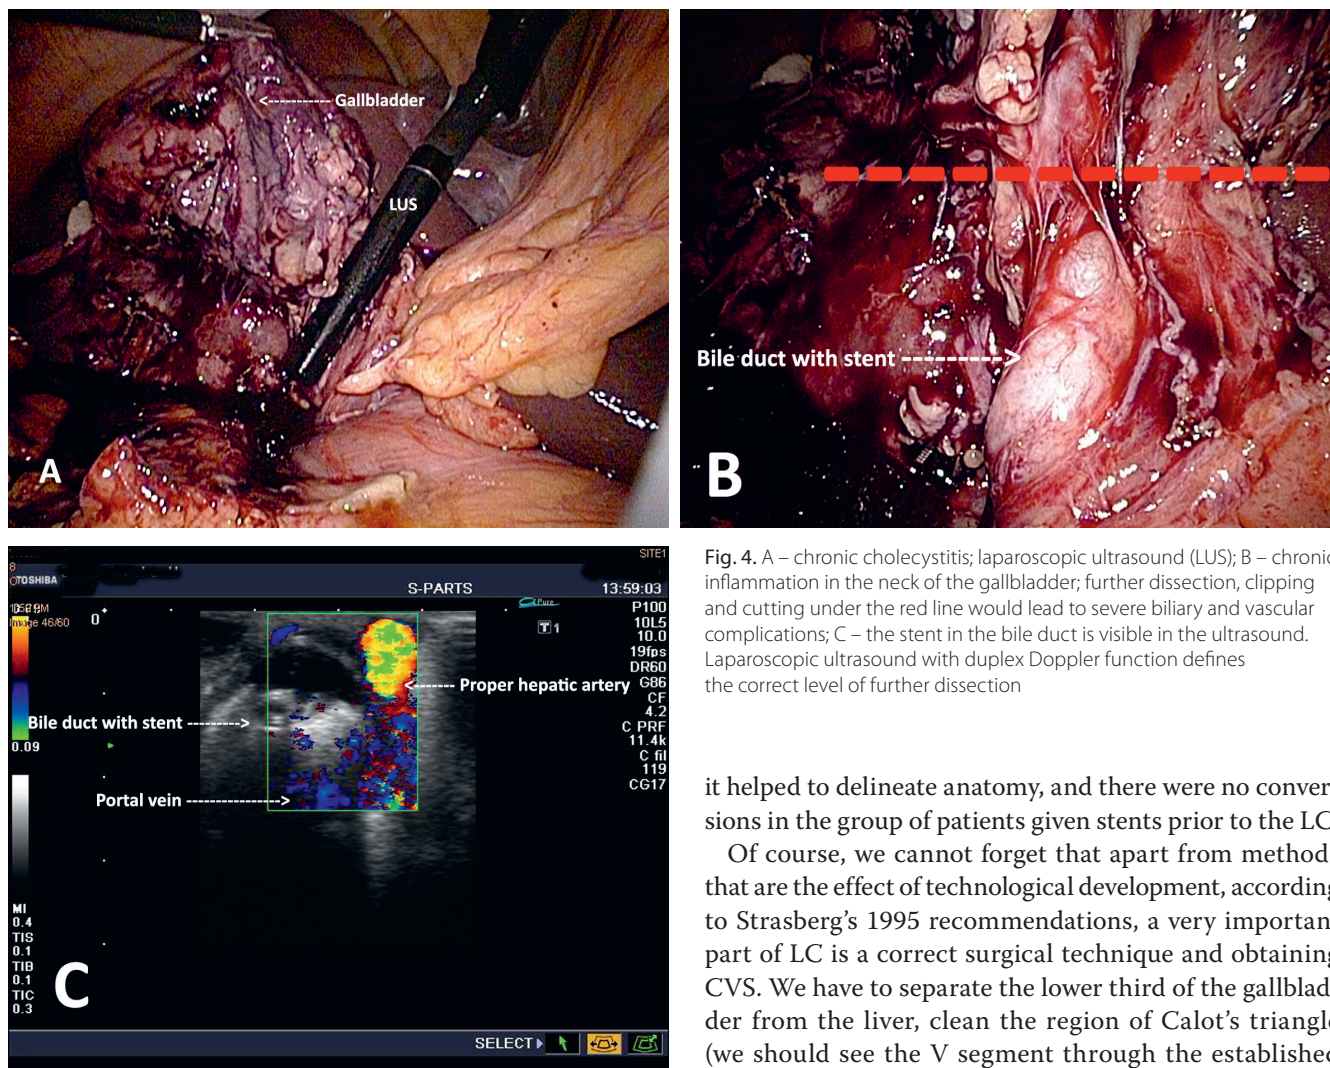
A – chronic cholecystitis; laparoscopic ultrasound (LUS); B – chronic inflammation in the neck of the gallbladder; further dissection, clipping and cutting under the red line would lead to severe biliary and vascular complications; C – the stent in the bile duct is visible in the ultrasound. Laparoscopic ultrasound with duplex Doppler function defines the correct level of further dissection
